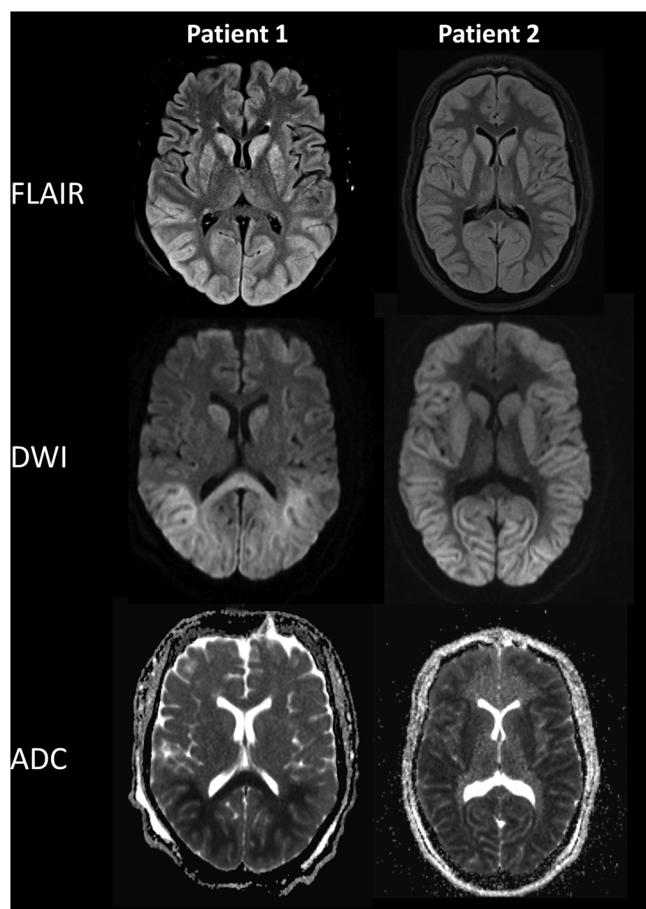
FLAIR, DWI and ADC images of 2 adult patients following cardiac arrest. Patient 1 shows FLAIR signal hyperintensities, diffusion and mass effects in the posterior parts of the brain on the second day after the event. The deep grey nuclei are also affected, but show less diffusion restriction. A second scan made 14 days after the event showed no diffusion restriction, while parenchymal gliosis could be seen on T2 imaging (figures not included). Patient 2 shows FLAIR signal hyperintensities, mass effects and diffusion restriction in all grey matter structures. This is an example of very severe global hypoxic brain damage.
